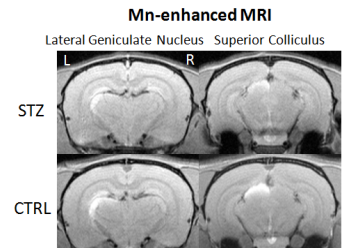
Mn-enhanced MRI of the subcortical visual nuclei at 1 day after Mn injection into right eye and 1 month after STZ or citric acid injection..
